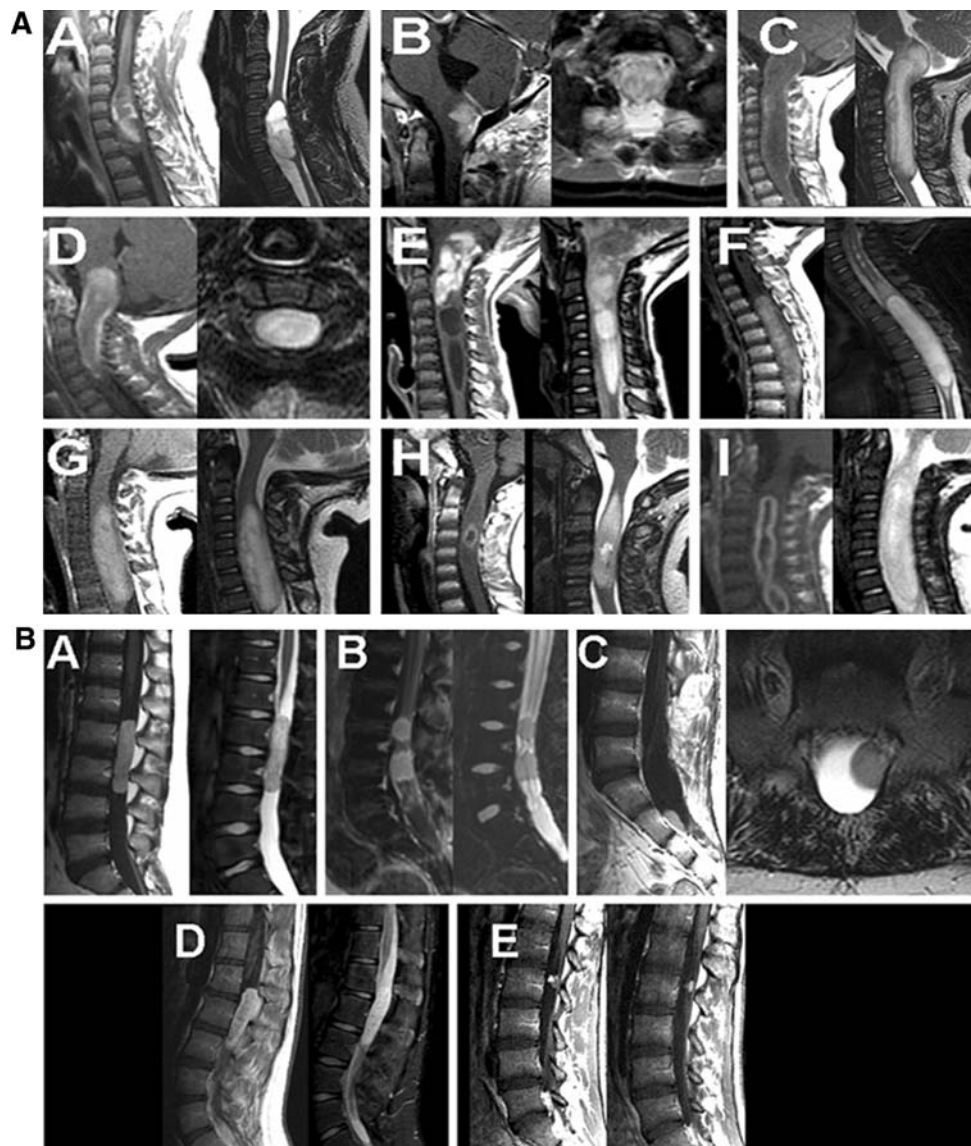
MRI characteristics of glial and ependymal primary spinal cord tumors (PSCT). Top panel a Pediatric spinal cord astrocytomas. A–E Pilocytic astrocytoma. Note the wide variability of imaging features. All lesions A–E are well-defined on T2 (T1)-weighted images. Only A and E have appearance of nodular enhancement in conjunction with a cyst, no cysts are seen in lesions B, C, D. The enhancement patterns vary from irregular (A, E), homogeneous (B), no significant enhancement (C) to rim-enhancement (D), the latter usually more typical of a higher grade lesions. F+G Fibrillary astrocytoma. These lesions share a pattern of sausage-like expansion of the spinal cord, similar to pilocytic astrocytoma C, but with diffuse
